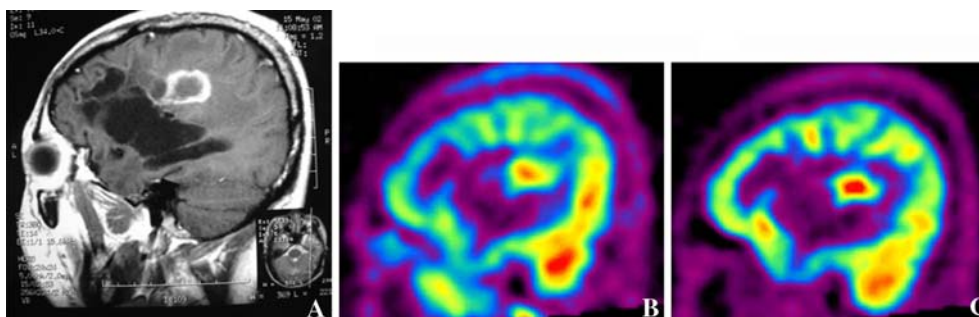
Thirty nine-year-old man (case 4) who had the resection and radiation therapy of a grade II astrocytoma 3 years ago. (A) T1-weighted gadolinium-enhanced MR image shows a ring-like
